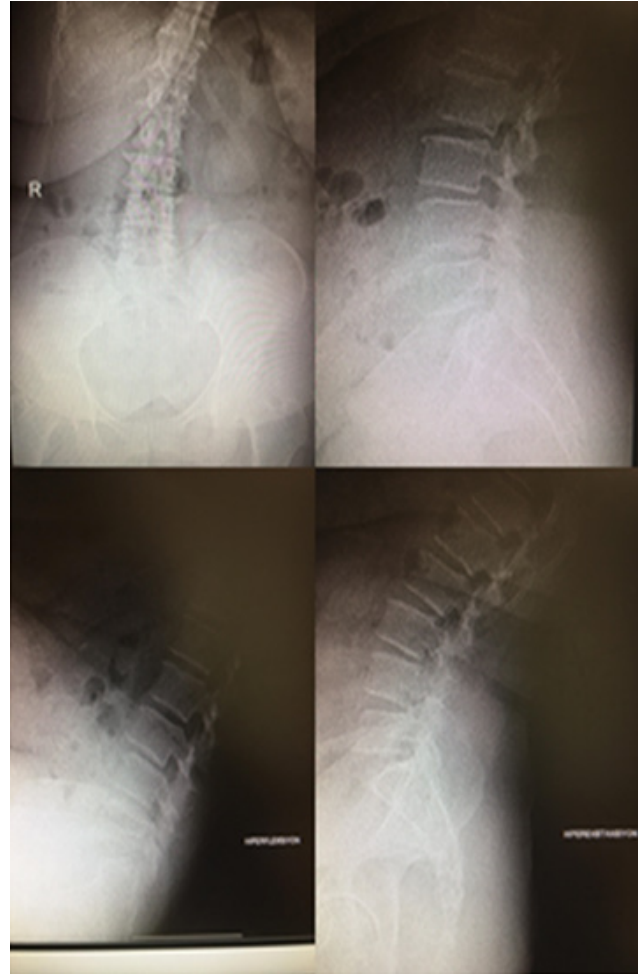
Preoperative roentgenogram
